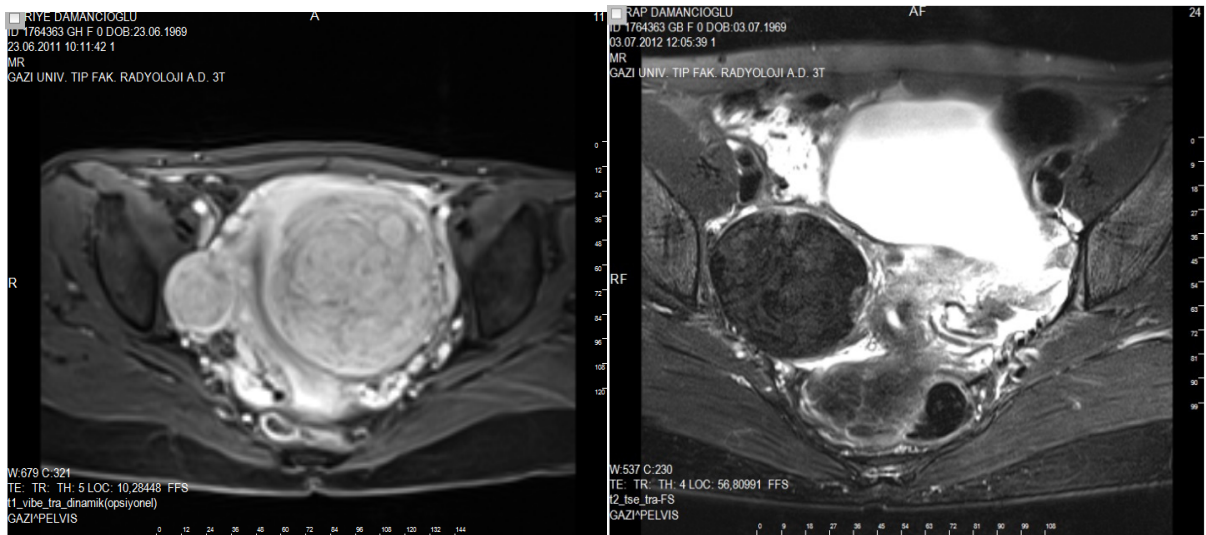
Patient SD: MR image of the pre and post-embolization leiomyoma.
